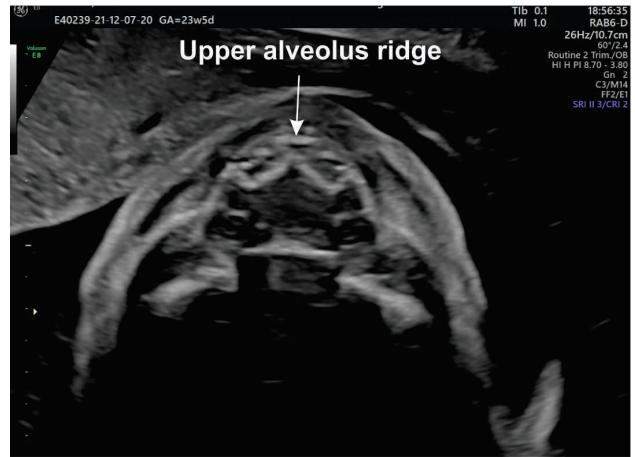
2D ultrasound imaging in a fetus of 23-24 weeks of gestation. Note the normal aspect of the inferior compartment of the face
